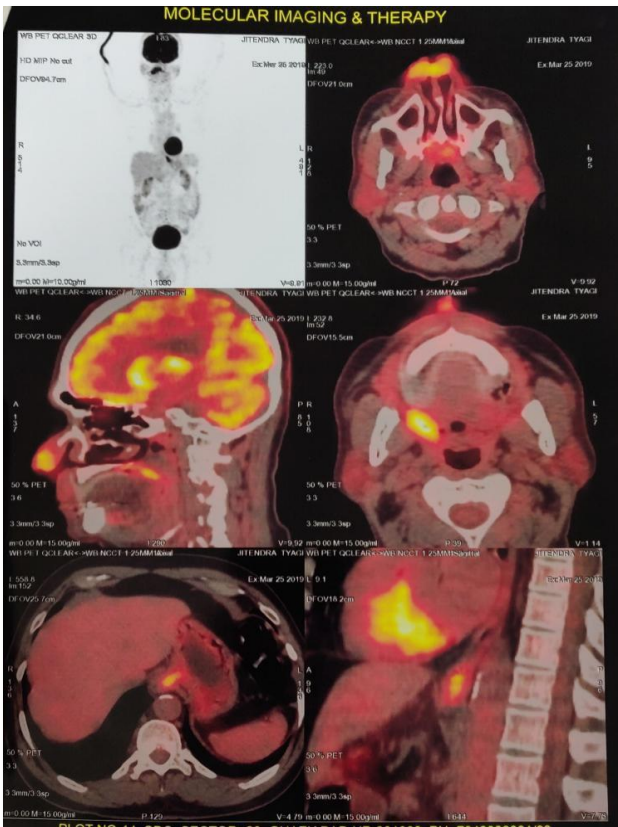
PET scan showing metabolically active, ulcerative soft tissue density lesion involving tip of the nose; increased FDG uptake in right tonsillar fossa can also be seen.
